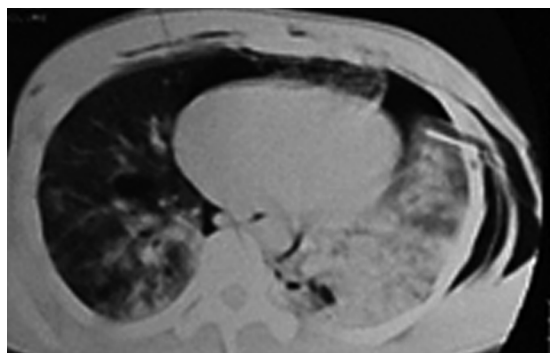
Computed tomogram shows consolidation throughout the left lung and posterobasal right lung, and chest-wall emphysema.
